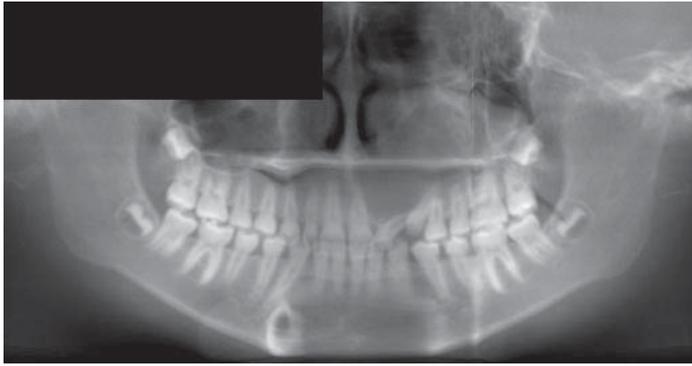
Panoramic image generated from CBCT data.
